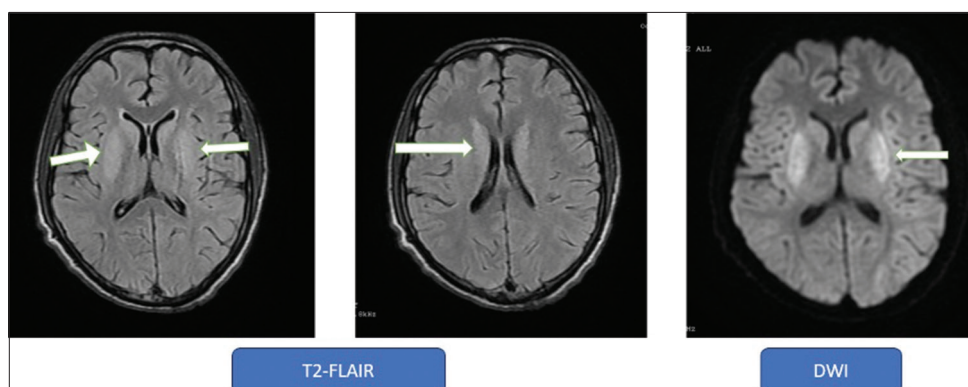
Magnetic resonance imaging brain showing bilateral putamen hyperintensities in T2-weighted image and fluid-attenuated inversion recovery sequences. Diffusion weighted imaging sequence showing restricted diffusion in the bilateral putamen and head of caudate nucleus
